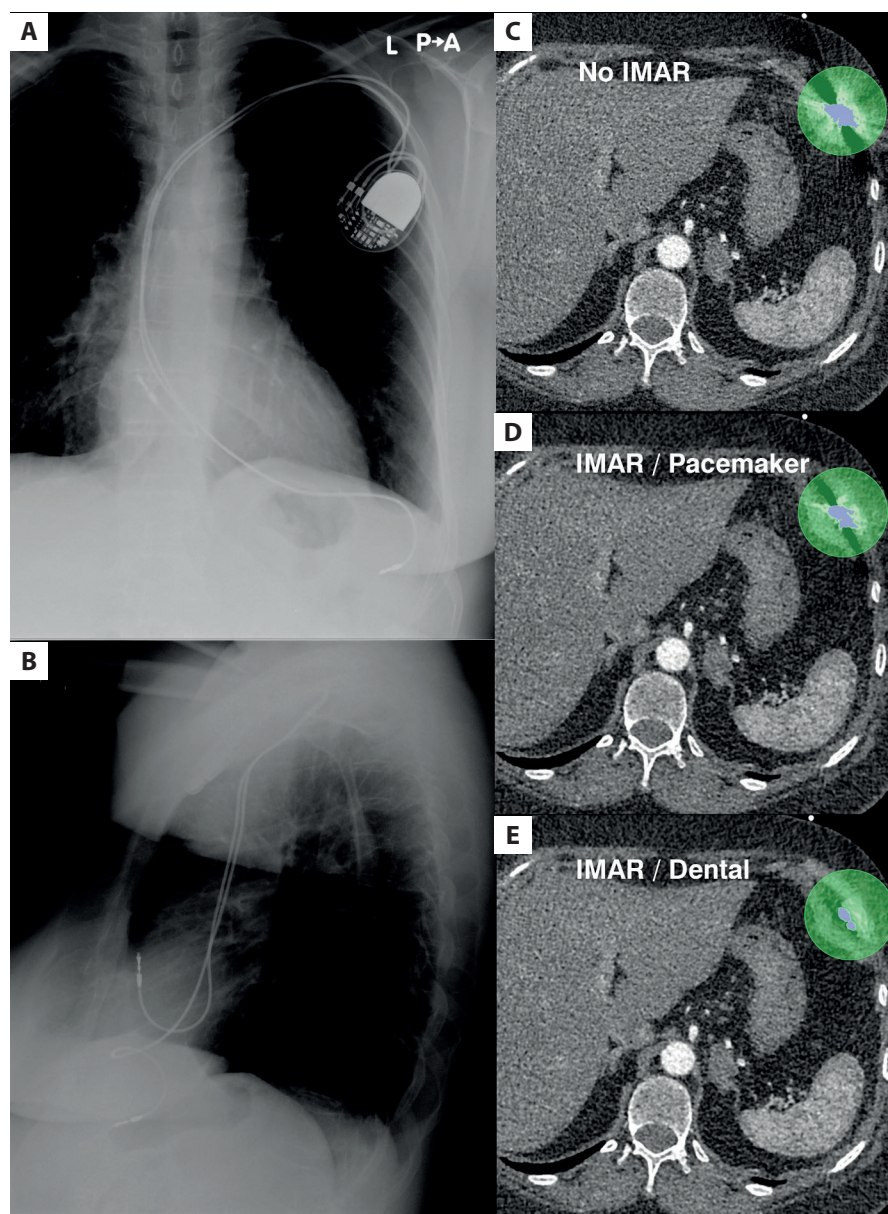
Posteroanterior (A) and lateral (B) chest X-ray shows the right ventricular lead projected under the left diaphragm. Native (C) and IMAR-filtered (D, E) computed tomography images showing reduction of the area of metallic artifacts around the lead tip, with best results with dental preset (E)
